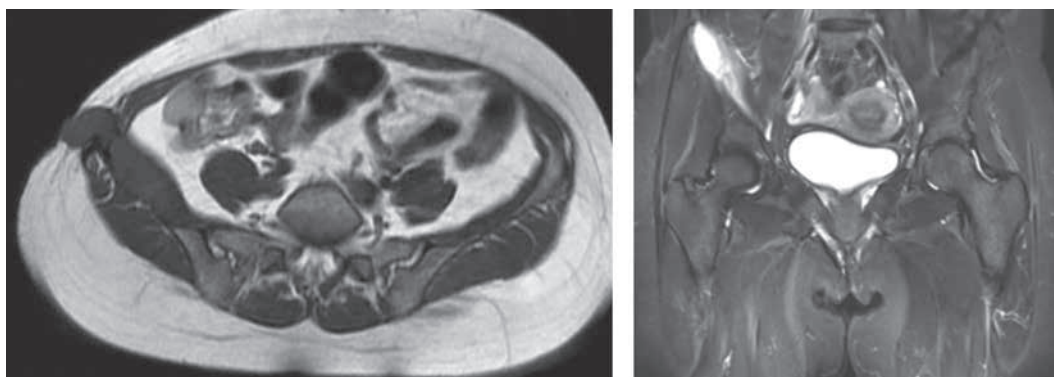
Same patient as in fig. 3. From left to right : T1-weighted axial and T2- weighted coronal image demonstrate intra- and extra-osseous extension of the lesion in the right ilium.
